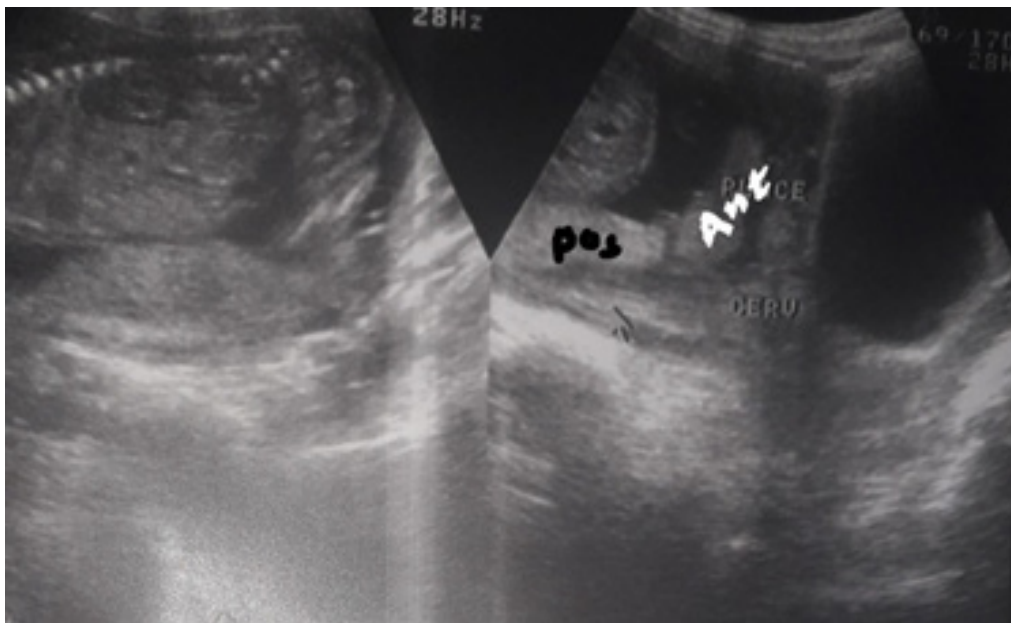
Ultrasound findings: Pos written in black represents the posterior bulk of the placenta and Ant written in white represents the accessory lobe of placenta.
